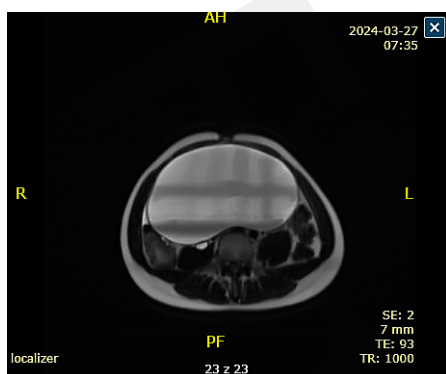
Magnetic resonance imaging (Case 1)
